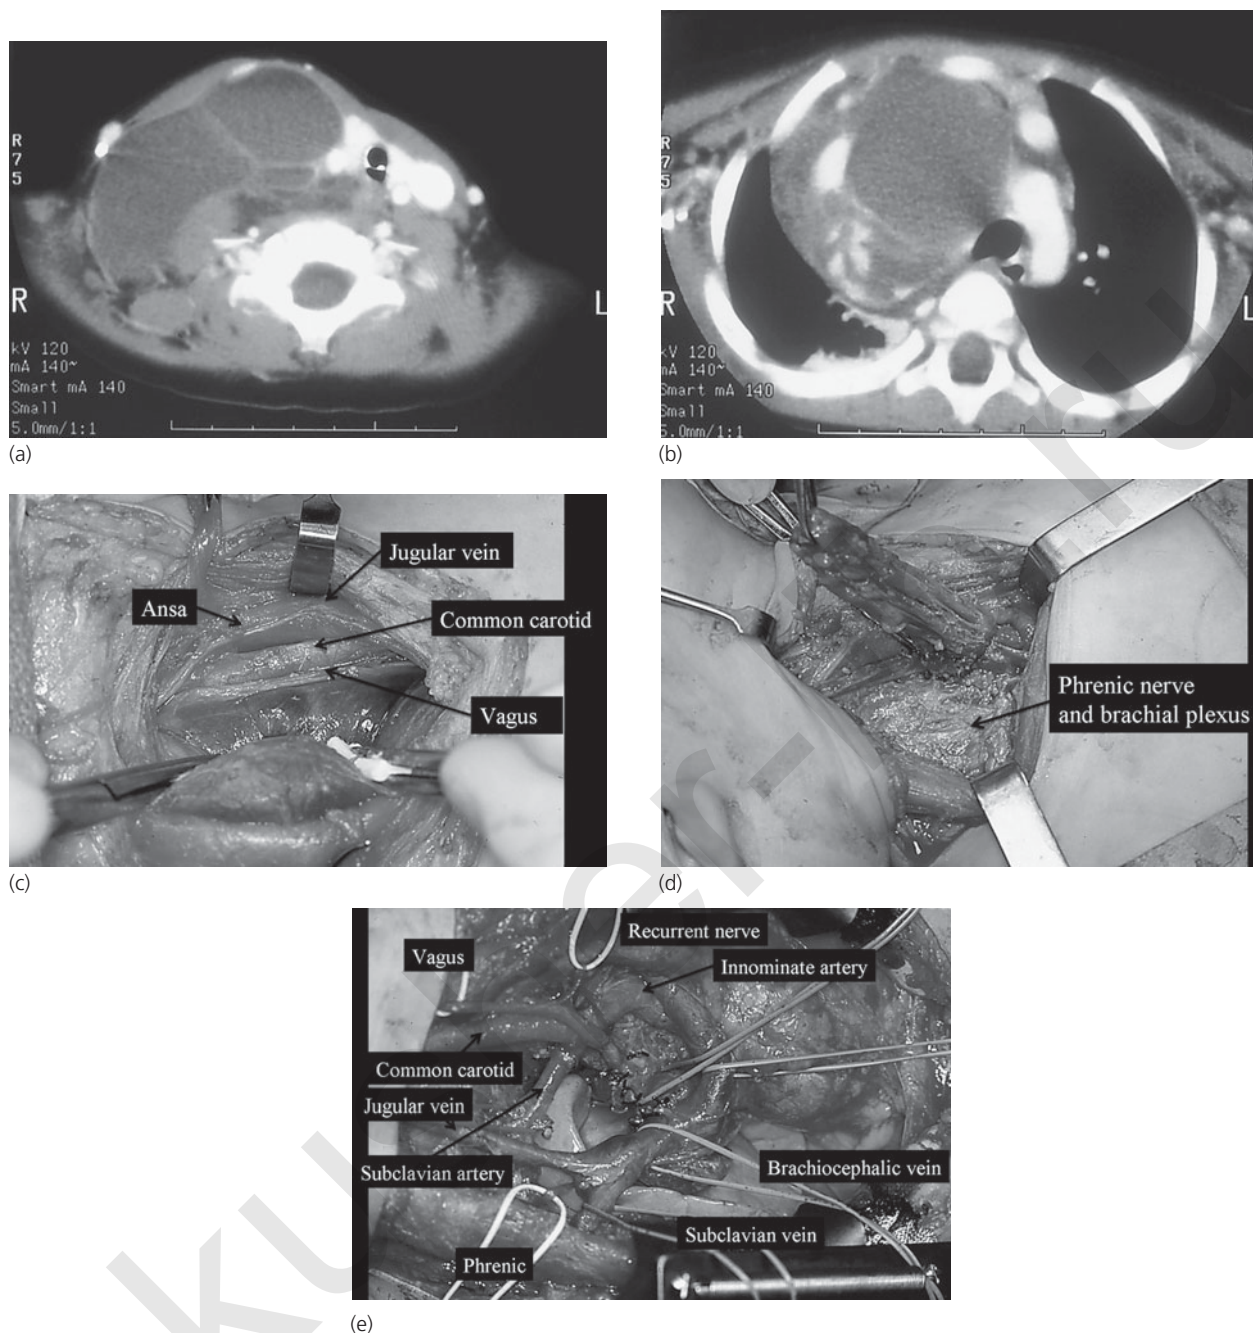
Surgical exposure of a cervico-mediastinal lymphatic malformation. Note location of vital neurovascular structures, which must not be damaged during the dissection. (a,b) Computed tomography scan demonstrating the lesion; (c,d) dissection of the cervical portion; (e) completed mediastinal dissection after extension of the incision and sternotomy.
